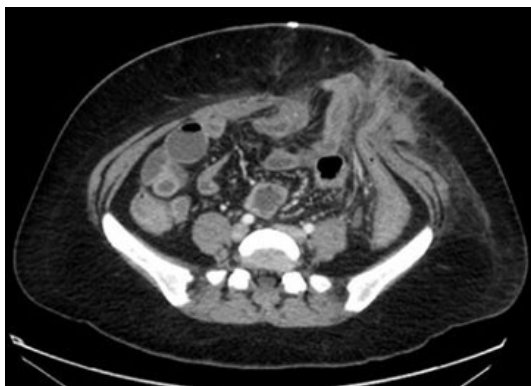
Repeat computed tomography scan at day 4 post-Hartmann's procedure showing the development of a parastomal hernia.
